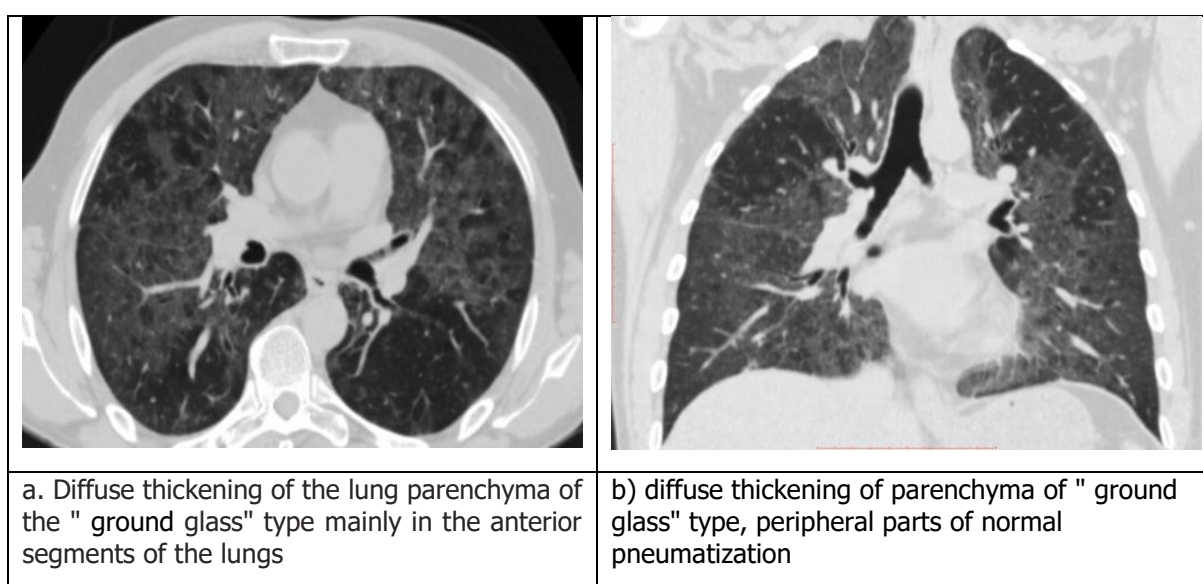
Patient with pneumocystis pneumonia, HIV positive. HRCT, pulmonary window, a) axial view b) coronal view
